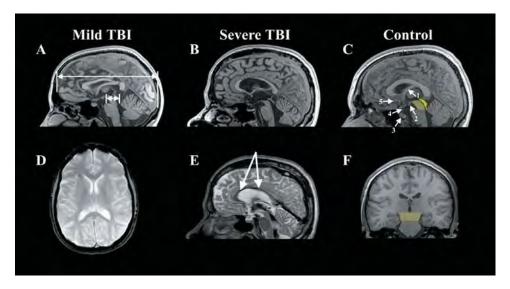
The top row presents mid-sagittal T1 MRIs comparing the fornix and corpus callosum from a control (C) to that observed in mTBI (A) and severe TBI (B). The control figure is labeled where the following structures are identified: (1) fornix, (2) mammillary body (3) pituitary, where it is situated in the sella turcica, (4) hypophysis of pituitary stalk, and (5) region of the basal forebrain. The light yellow depicts the region of the tegmentum of the midbrain (shown in coronal view in F), whereas the darker yellow represents the tectal region of the midbrain. The coloration of the midbrain is also done to highlight the relative smallness of the mibrain compared to the size of the cerebrum, and how the cerebrum 'rests' atop the midbrain. As shown in (A) from the patient with mTBI, the length of the cerebrum (long arrow) is approximately 10 times the length of the midbrain (short arrow). (D) depicts an axial gradient recall echo (GRE) depicting multiple deposits (black dots) of hemosiderin in the frontal region, implicating shear injury, note how they are mostly located at the gray-white matter junction. This patient had sustained an mTBI in a MVA. Note that there is thinning of the corpus callosum and a shear lesion in the isthmus region. (E) is a T2 mid-sagittal MRI depicting extensive hemosiderin deposition along the body of the corpus callosum (arrows) and also note the generalized atrophy of all structures in the severe TBI case compared to the mTBI and control.
